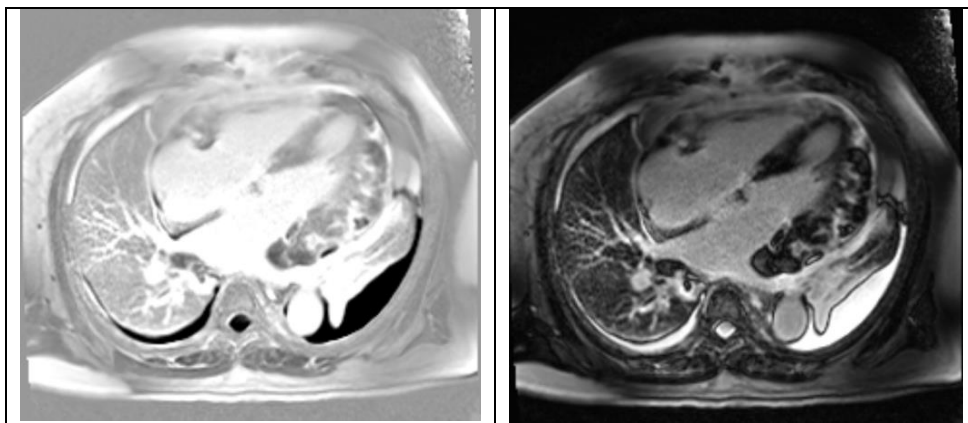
Late Gadolinium Enhancement (LGE) cardiac magnetic resonance imaging demonstrating infiltrative thickening of the lateral and anterior left ventricular myocardium with heterogeneous late gadolinium enhancement, myocardial edema and intramyocardial hemorrhagic change, highly suggestive of infiltrative malignancy (Left: phase-sensitive inversion recovery; right: magnitude reconstruction).
